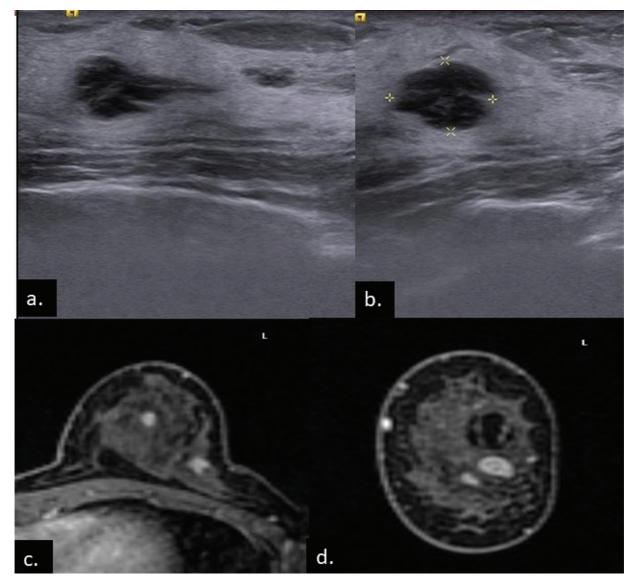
A 52-year-old female patient presented with left breast lump. On US (a and b) at approximately, 3 to 4 o'clock A position, there is an inhomogeneous area of low echogenicity, with few smaller adjacent nodules seen in this region. (c and d) CEMRI revealed nodular lesion showing inhomogeneous enhancement in the lower outer quadrant, revealing type I curves on further interrogation. Biopsy from the largest area of abnormality at 3–4'o clock position revealed lymphoma. CEMRI, contrast-enhanced magnetic resonance imaging.
